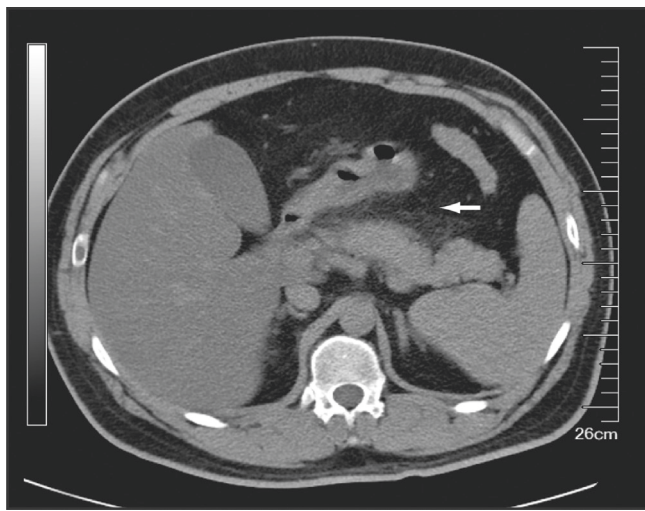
Computed tomographic image of the abdomen after treatment shows a clinically significant reduction in peripancreatic fluid (arrow).
